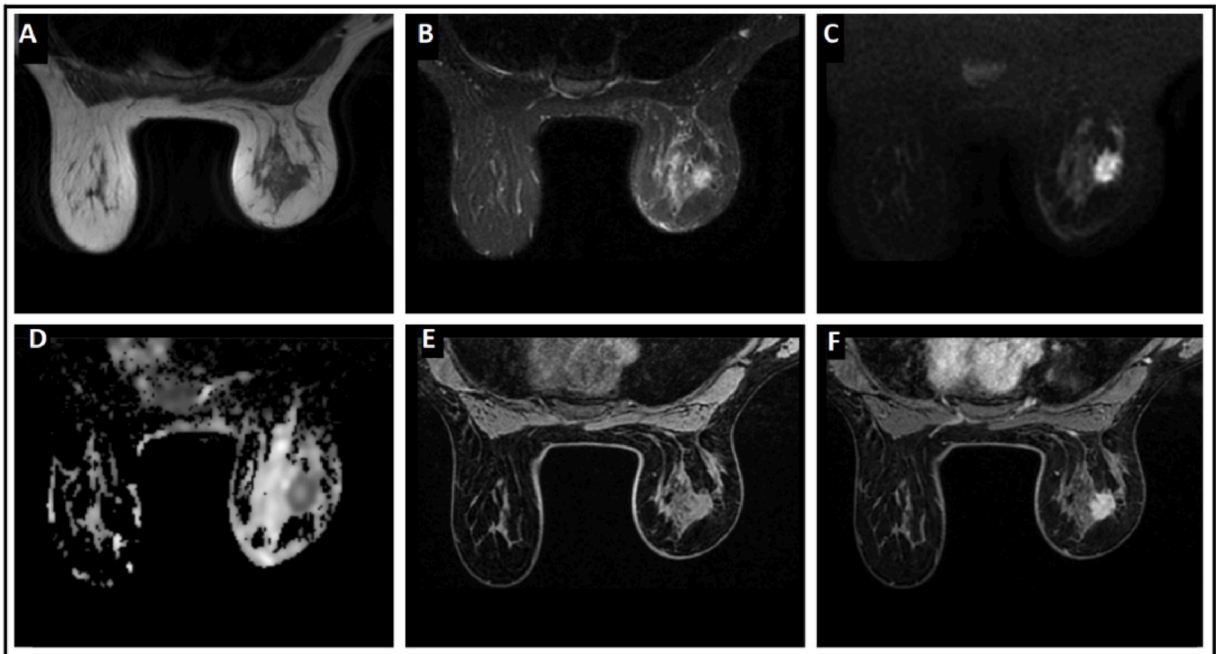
46-year-old woman with invasive ductal carcinoma in right breast. Spiculated contoured mass lesion in the upper outer quadrant on T1-weighted (A), fat-suppressed T2-weighted (B), b: 800 s/mm² DWI (C), ADC map (D), fat-suppressed precontrast T1-weighted (E), and fat-suppressed post-contrast T1-weighted (F) axial section MR images.
